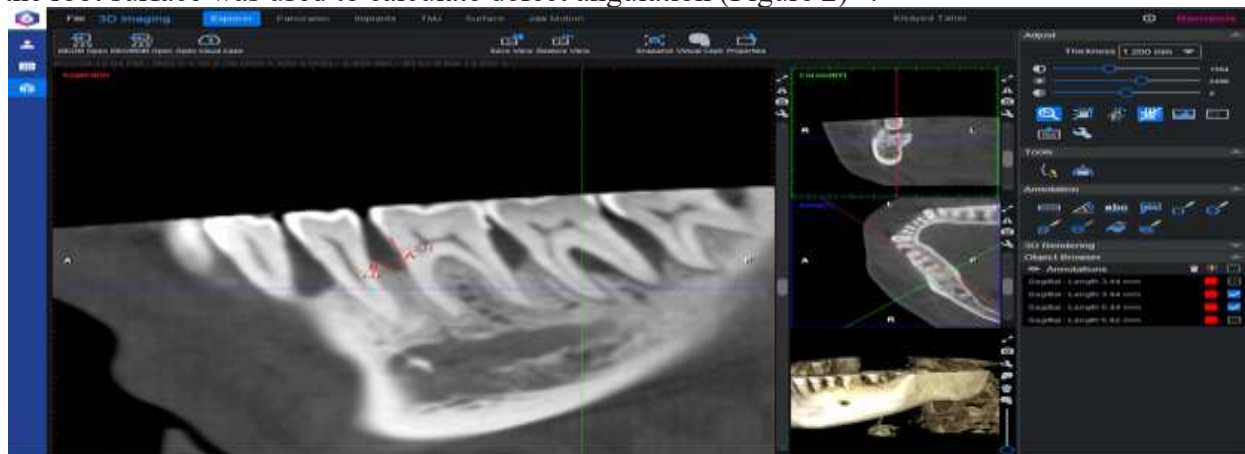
CBCT sagittal cut showing Linear measurements of an intrabony defect at mesial aspect of upper right first premolar before therapy: first line A) length from CEJ: cemento-enamel junction; BD: most apical extension of the bony defect. The second line B) AC: alveolar crest; BD: most apical extension of the bony defect.
